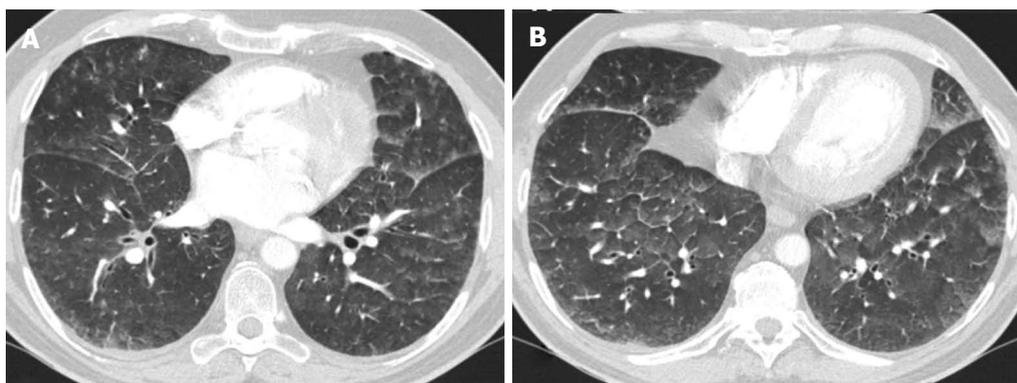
Computed tomography scan through lower lobes shows, limited areas of ground-glass opacity, with thickening of major fissures reflecting subpleural interstitial edema. Is also present interlobular septal and peribronchovascular interstitial thickening.
